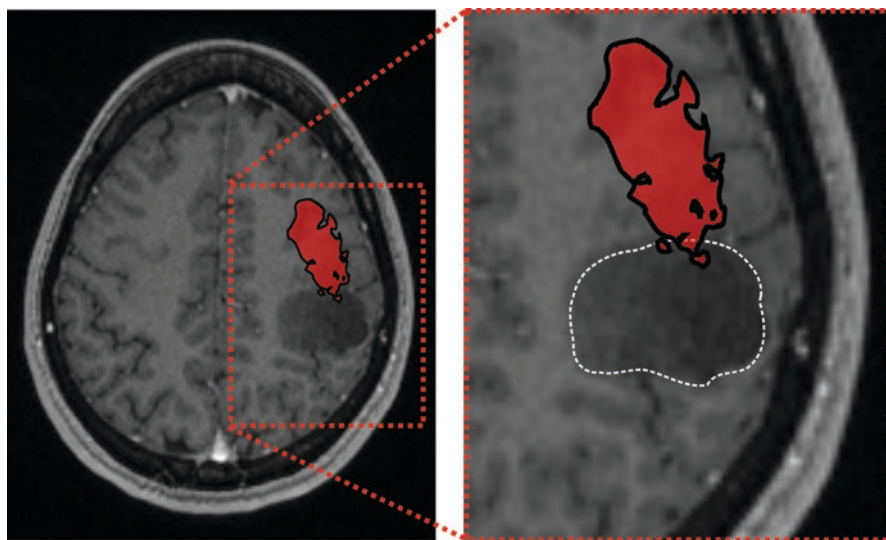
Example of an outlined cortical map of hand muscle function on the M1 overlaid on an axial MRI slice. The functional area is represented as *red*, and the tumor and affected anatomical structure is outlined with a *white dashed line* in the close-up on the right. Outlining was performed using spline interpolation of MEP amplitudes (Julkunen 2014)
